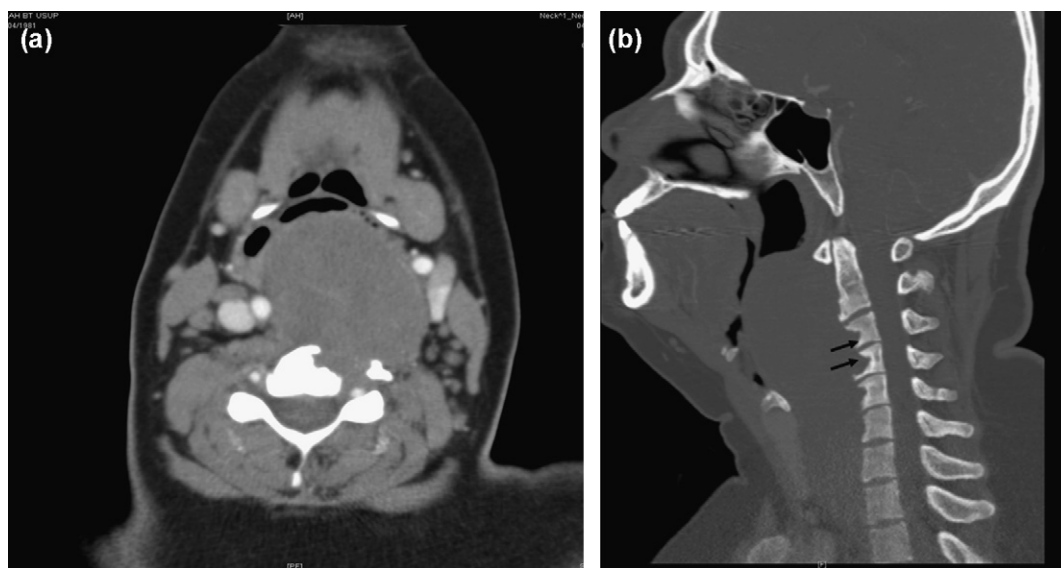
CT in (a) axial soft tissue and (b) sagittal bone window show a well demarcated and homogeneous retropharyngeal mass more towards the left with smooth margins causing narrowing and displacement of the larynx and pharynx. There is associated bony erosion of the anterior vertebral bodies (arrows). The neural foramen is not widened. Small cervical lymph node noted.
